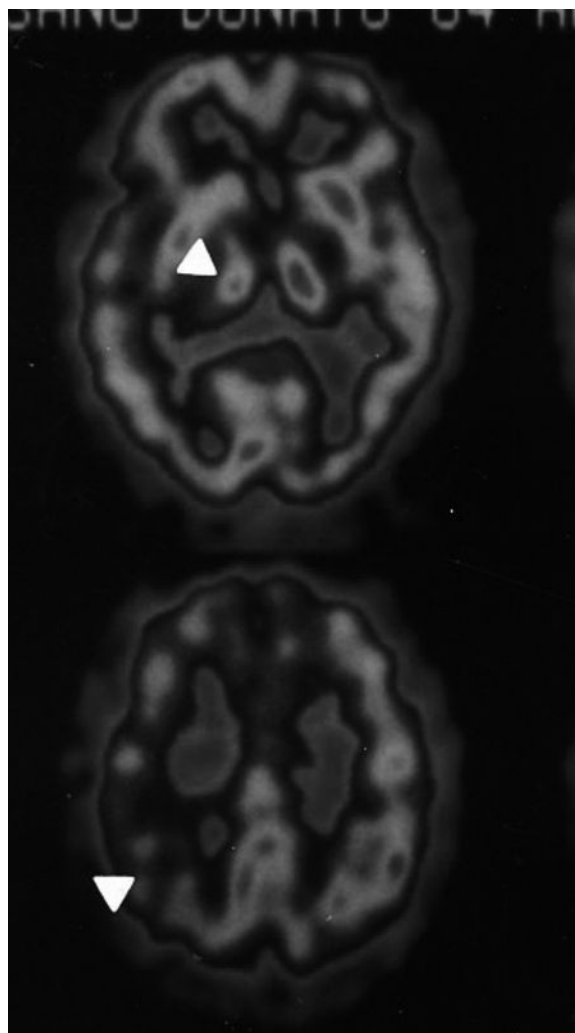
High-resolution SPECT (double-head camera) images of post-cordotomy CP. Note both thalamic (upper scan, arrowhead) and parietal hypoperfusion (lower scan, arrowhead). See color plate section.
